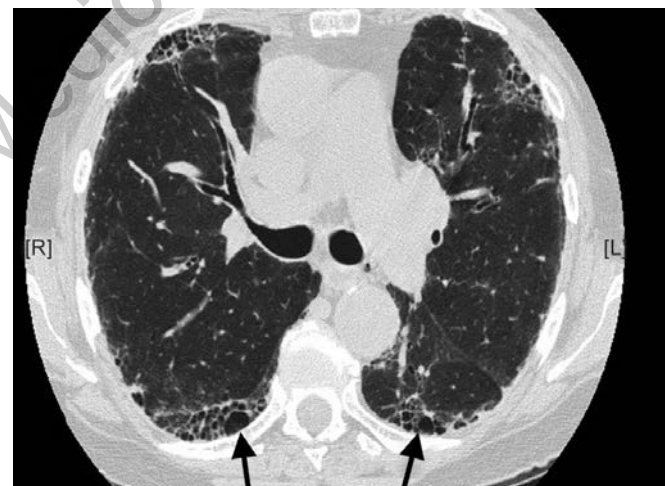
HRCT demonstrating cystic changes in the subpleural regions (arrows) resulting in a honeycombing pattern in a patient with idiopathic pulmonary fibrosis. Note dilated bronchi (right upper lobe dilated bronchi) and paucity of ground glass opacity
